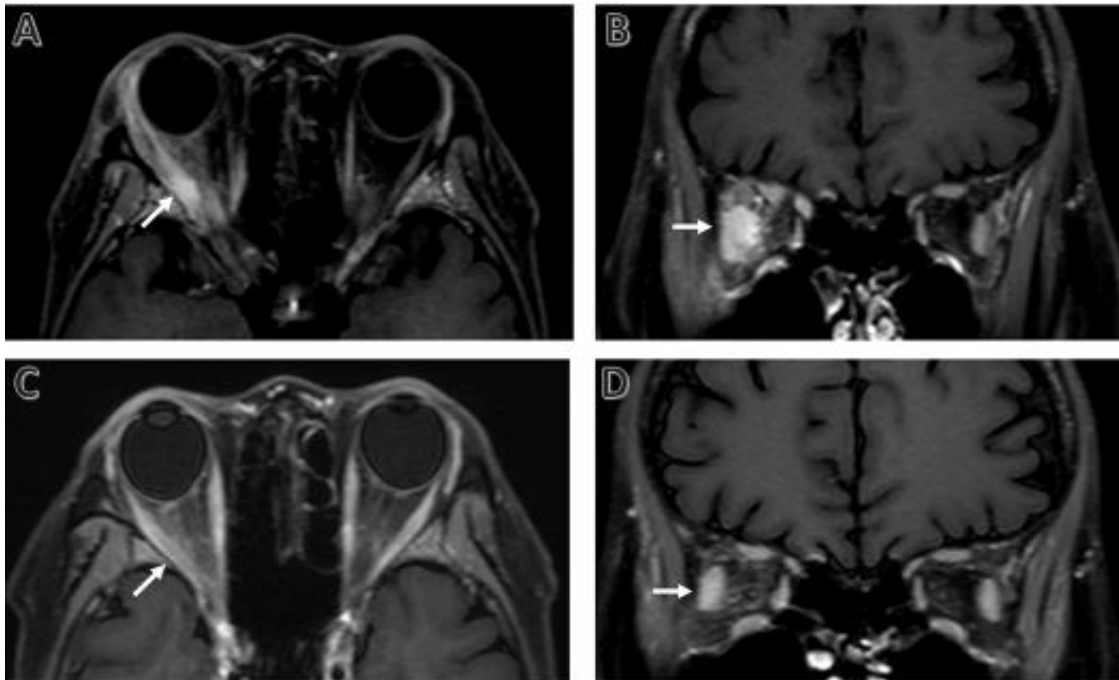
Orbital contrast-enhanced STIR- MRI. (A) Axial fat-suppressed contrast-enhanced T1 shows severe lateral rectus muscle swelling, contrast enhancement in right eye. (B) Coronal fat-suppressed contrast-enhanced T1 shows severe lateral rectus muscle swelling, contrast enhancement and rectus superior muscle swelling in right eye. (C) and (D): On 14 day; (C) Axial fat-suppressed contrast-enhanced T1 shows the disappearance or remarkable decrease of the abnormalities in right eye. (D) Coronal fat-suppressed contrast-enhanced T1 shows the disappearance or remarkable decrease of the abnormalities in lateral rectus muscle. Arrows indicate lateral rectus muscle in right eye
